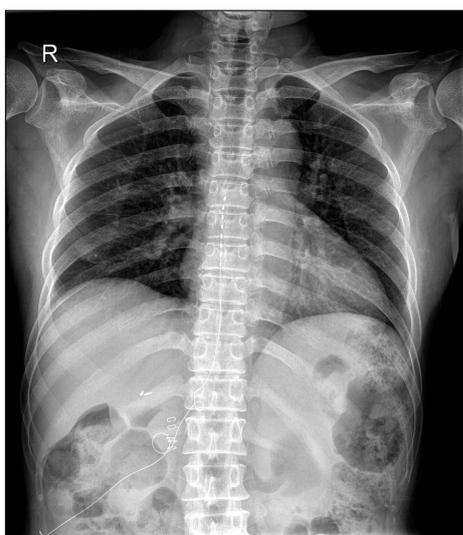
Anteroposterior radiograph showing a SCS lead placement at T5-7.
